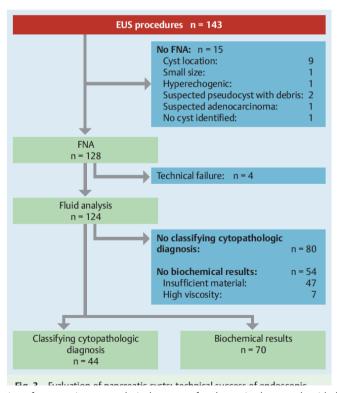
Evaluation of pancreatic cysts: technical success of endoscopic ultrasound-guided fine needle aspiration (EUS – FNA)
